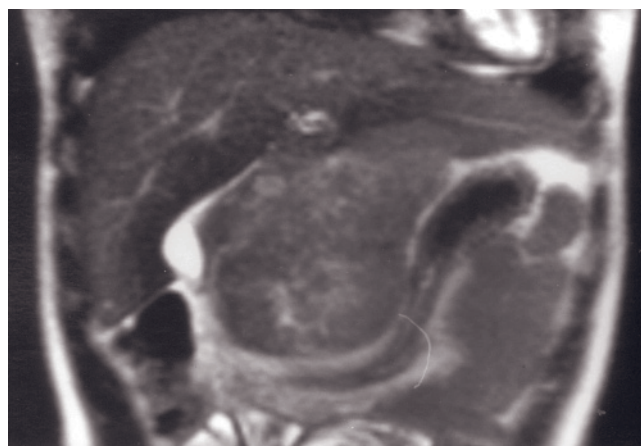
Hepatoblastoma. Fat-suppressed T2-weighted ETSE (a), T1-weighted fat-suppressed SE (b), and T1-weighted 90-s fat-suppressed SE (c) images in a 2-month-old boy. There is a large, slightly lobulated mass arising from the liver, which demonstrates slightly increased signal intensity on T2 (a), mildly decreased signal intensity on T1(b), and mildly heterogeneous enhancement on interstitial-phase gadolinium-enhanced (c) images. Note that the mass displaces the celiac axis, the right kidney, aorta, inferior vena cava, and pancreas.
